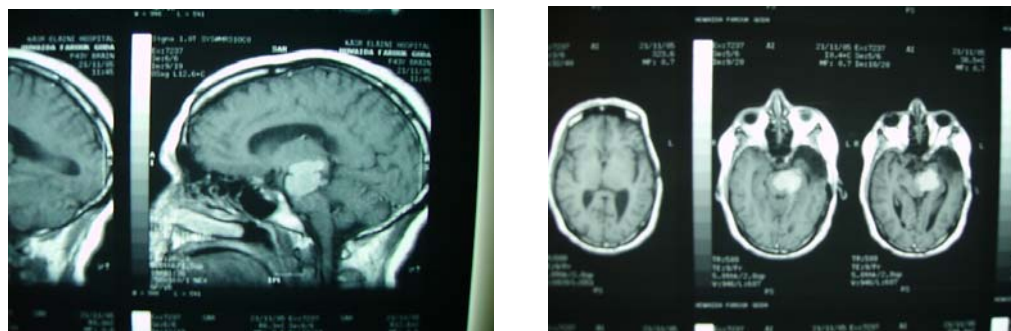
Showing axial CT with contrast, and sagittal MRI with contrast of a giant right tentorial meningioma (case no. 1).Fig. (2): Showing postoperative CT of the above patient (case no.1). Total excision was achieved.*
